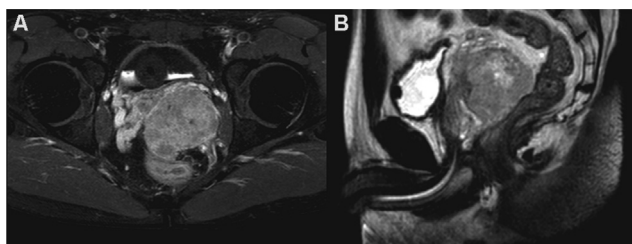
The 6.0 cm × 4.5 cm × 4.6 cm mostly solid pelvic mass on T1-weighted, contrast-enhanced (A) as well as T2-weighted MRI-study (B). It shows signs of central necrosis and displacement of bladder and rectum with suspected infiltration of the prostate and left internal obturator muscle; partly contrast-filled bladder with placed foley catheter.
